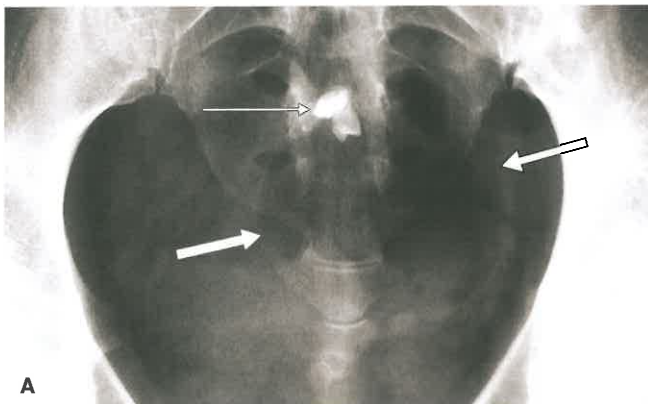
Benign Cystic Teratoma. A: Conventional radiograph of the pelvis in a young woman demonstrates several well-formed teeth (*skinny arrow*). A subtle, well-defined mass of fat density is also present (*fat arrows*). These findings are diagnostic of benign cystic teratoma. B: CT performed without contrast of a 28-year-old woman reveals a fat-density mass (*arrow*) diagnostic of a benign cystic teratoma.
